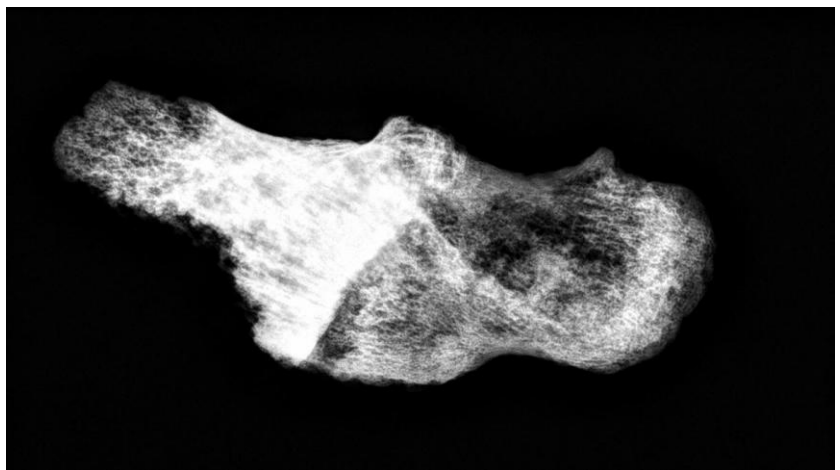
Radiography of the fused right calcaneus with the right navicular of SEP42, superior view, excavation of 1997-1998, Collège Claude Monet, Magny-en-Vexin, France.
